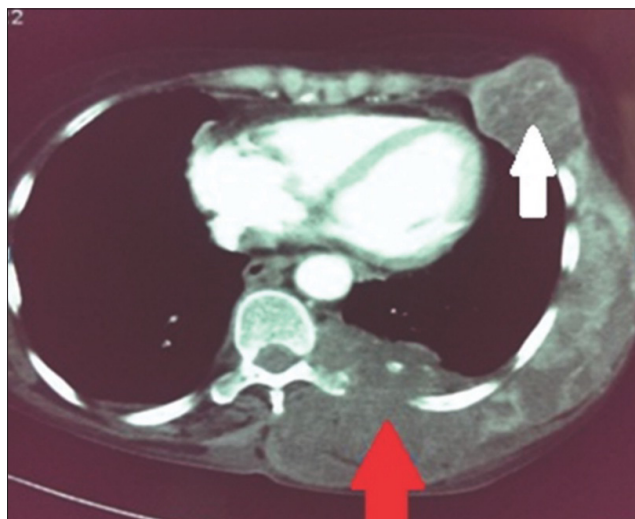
Contrast enhanced computed tomography-thorax showing skeletal muscle metastasis in the paraspinal and intercostal muscles invading the vertebra (red arrow) and lung metastasis (white arrow)
